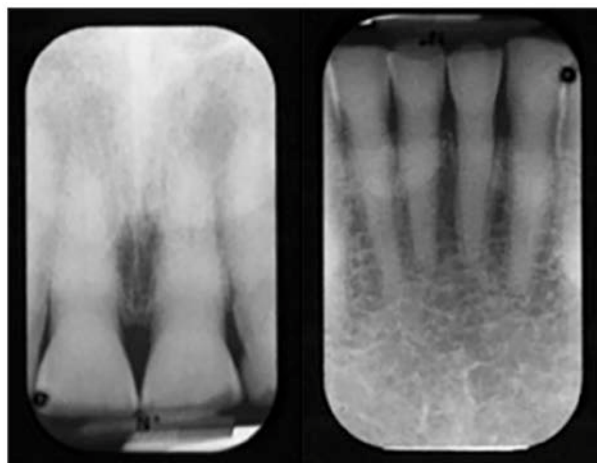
Periapical radiographs showing secondary dentin deposition likely due to attrition.
